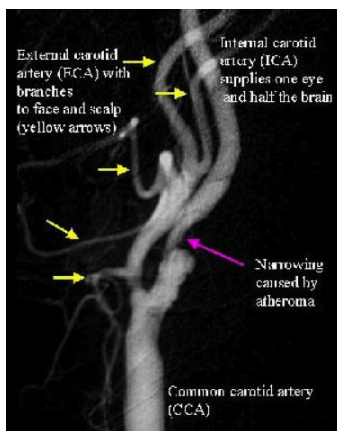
Image of CT Angiogram demonstrating significant stenosis of the proximal ICA caused by the formation of atheromatous plaque.
